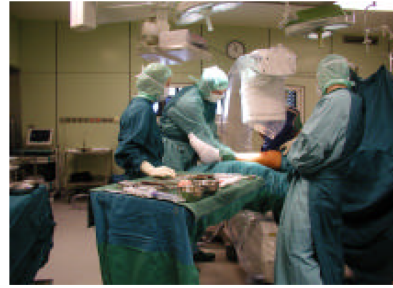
Control of reposition with intraoperative 3D radiography, here the scan showed a remaining gap and the reduction had to be performed again
